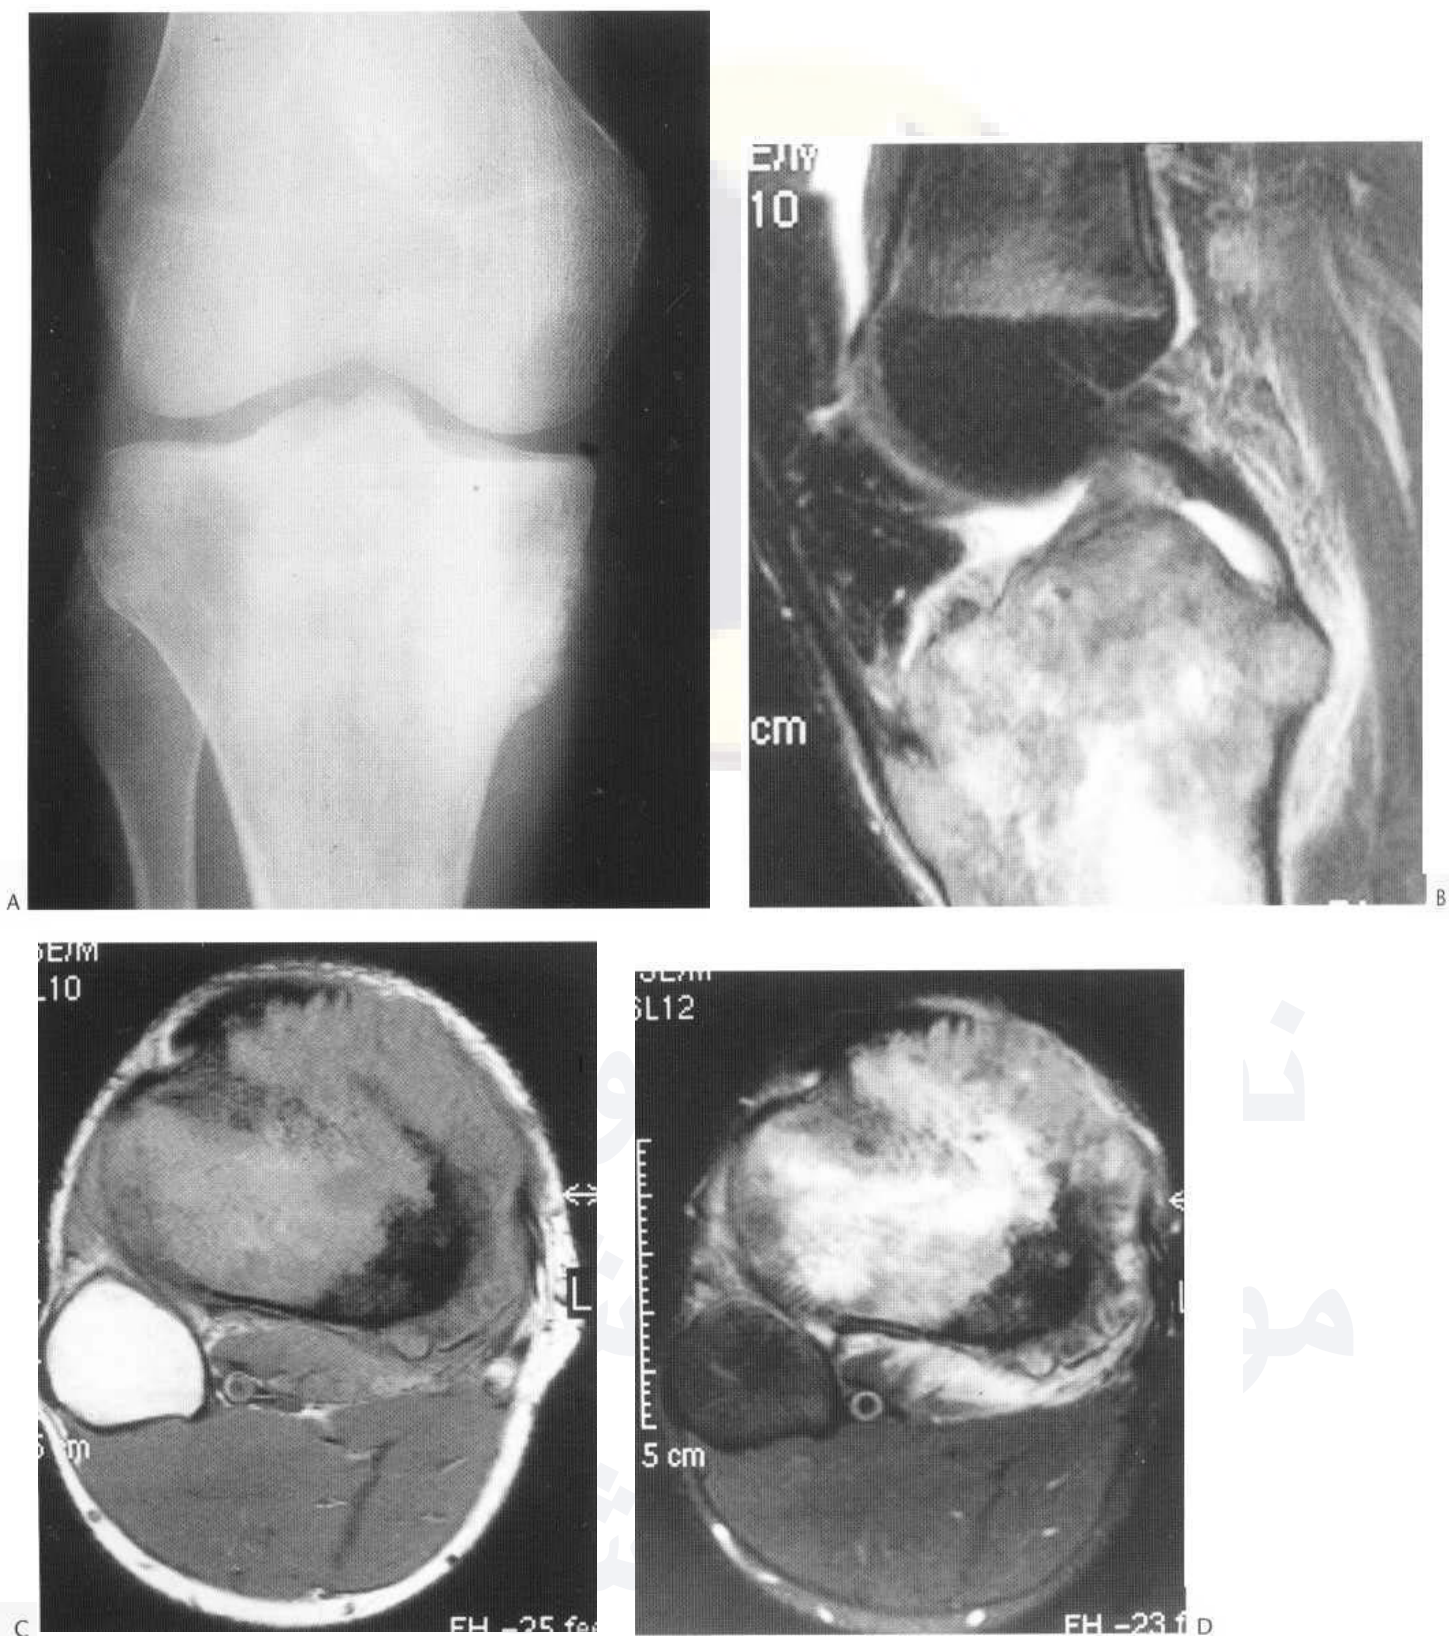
Osteosarcoma of the proximal tibia. (A) Conventional radiograph showing an osteoblastic lesion with periosteal new bone medially. (B) Sagittal turbo T₁-weighted image with fat suppression. (C) Axial T₁-weighted image with fat suppression. (D) Axial turbo T₂-weighted image with fat suppression. The MR images elegantly demonstrate the heterogeneity of the tumour, the intramedullary involvement (note the normal fatty marrow within the distal femur and proximal fibula), periosteal new bone and involvement of the tibia origin of the patellar tendon. Perilesional oedema and a joint effusion are also evident.
